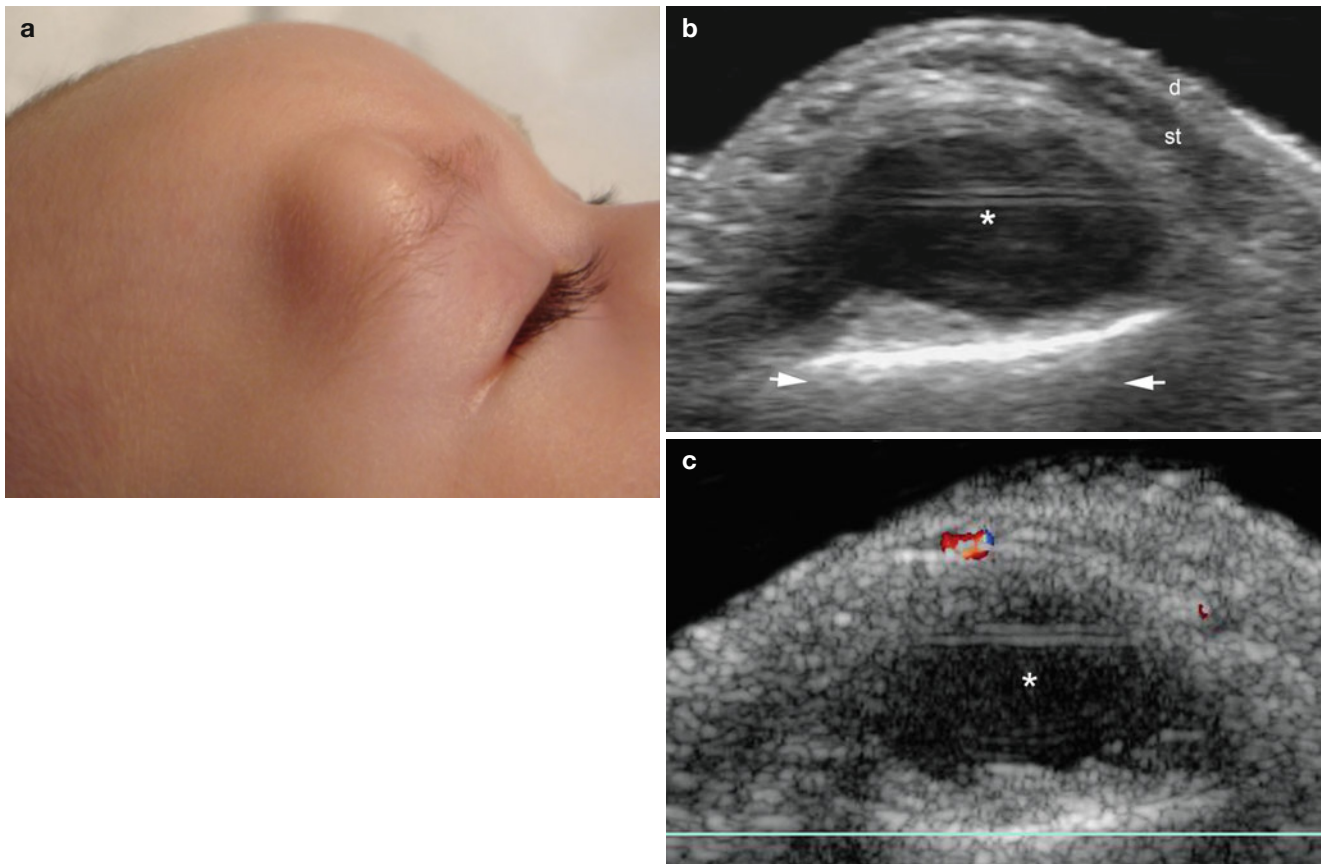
(a–c) Large dermoid cyst. (a) Clinical image shows a swelling in the right ciliar region. (b) Ultrasound image (gray scale, transverse view) demonstrates well-defined *oval-shaped* anechoic cystic
